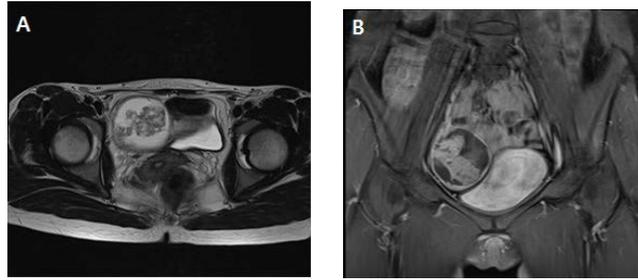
Pelvis Magnetic Resonance Imaging image shows a large multi-cystic mass measuring approximately 5.8×5.5×5.5 cm in size, with an enhancing irregular thick wall and an amorphous enhancing solid portion with low signal intensity in the right pelvic cavity. (A) Coronal view and (B) axial view.
